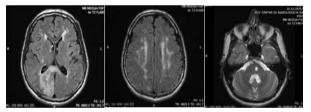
Subacute extensive lesion located occipitally on the right and in the corpus callosum splenium; confluent, partly discrete hyperintense lesions on T2 FLAIR in frontoparietal subcortex and periventricularly; chronic lacunar ischemia of the pons
